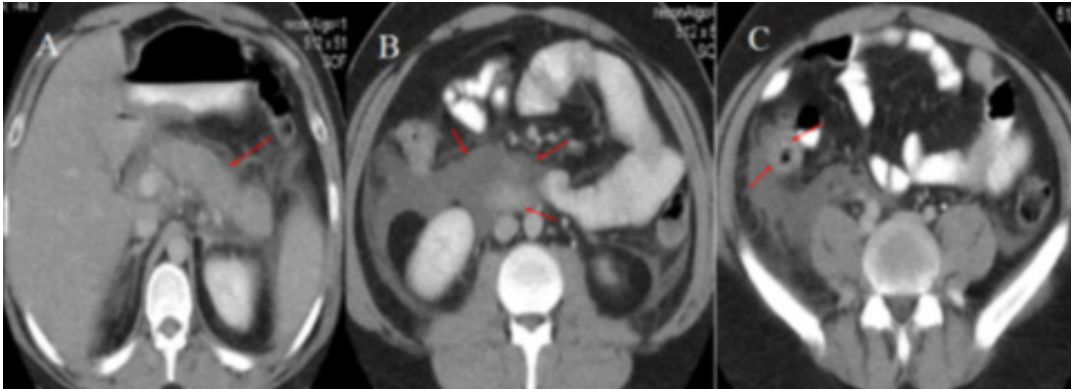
Abdominal CT scan, evidence of inflammation in the pancreas (A) with fluid accumulation in the mesentery (B) and around the inflamed appendix (C).
